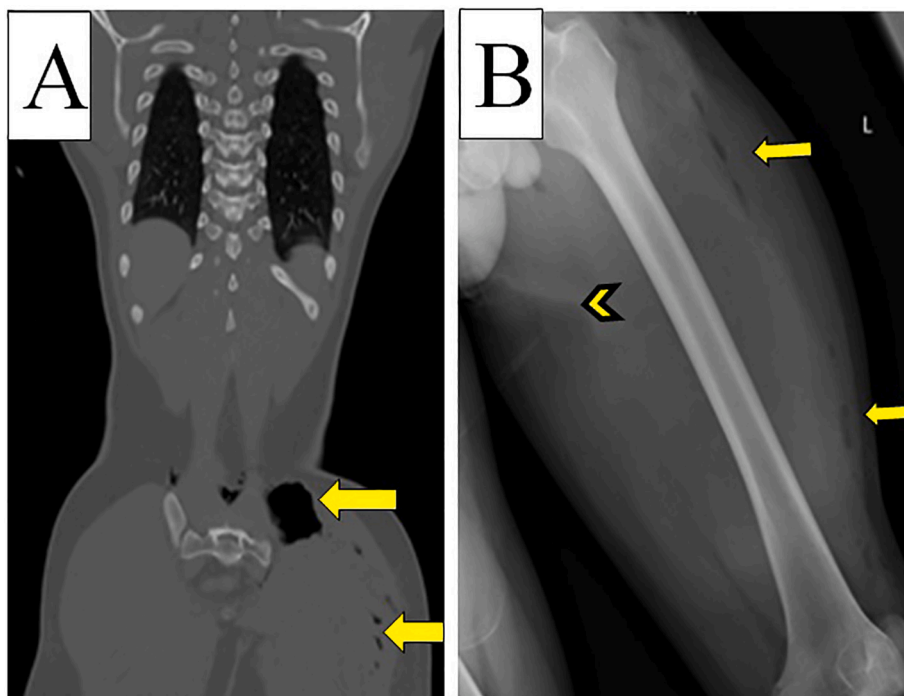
Image A Trauma CT scan in coronal view depicting a large air containing fluid collection over the left gluteus maximum muscle (arrow). Image B X-ray left femur depicting multiple air pockets (arrows) and hematoma in the soft tissue of the left thigh (arrowhead).
